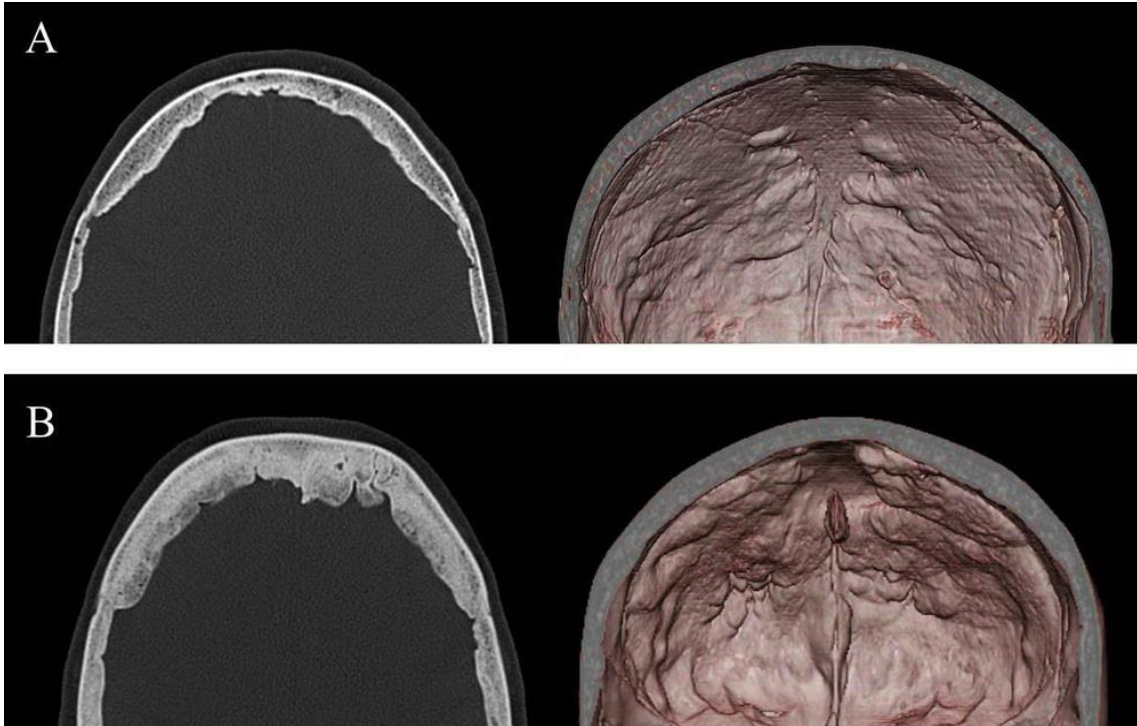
CT scans of the skull (A-moderate HFI, B-severe HFI). Axial scans in the bone window (left) and 3D reconstruction images (right), demonstrating the thickening of the inner table of the frontal bone.
